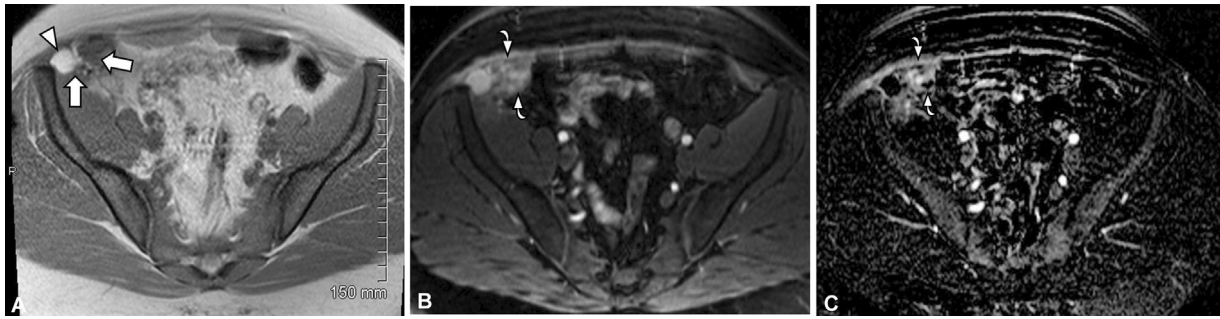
A 41-year-old woman with history of laparoscopic hysterectomy 18 months prior and right lower abdominal wall mass and pain. (A) Axial T1-weighted magnetic resonance (MR) image shows a heterogeneous mass (arrows) at a laparoscopy port site with area of T1 hyperintensity (arrowhead). The mass (curved arrows) is predominantly hyperintense on the (B) axial short-tau inversion recovery (STIR) MR image and has heterogeneous enhancement on the (C) axial subtraction MR image. Biopsy showed endometrial tissue consistent with scar endometrioma.
